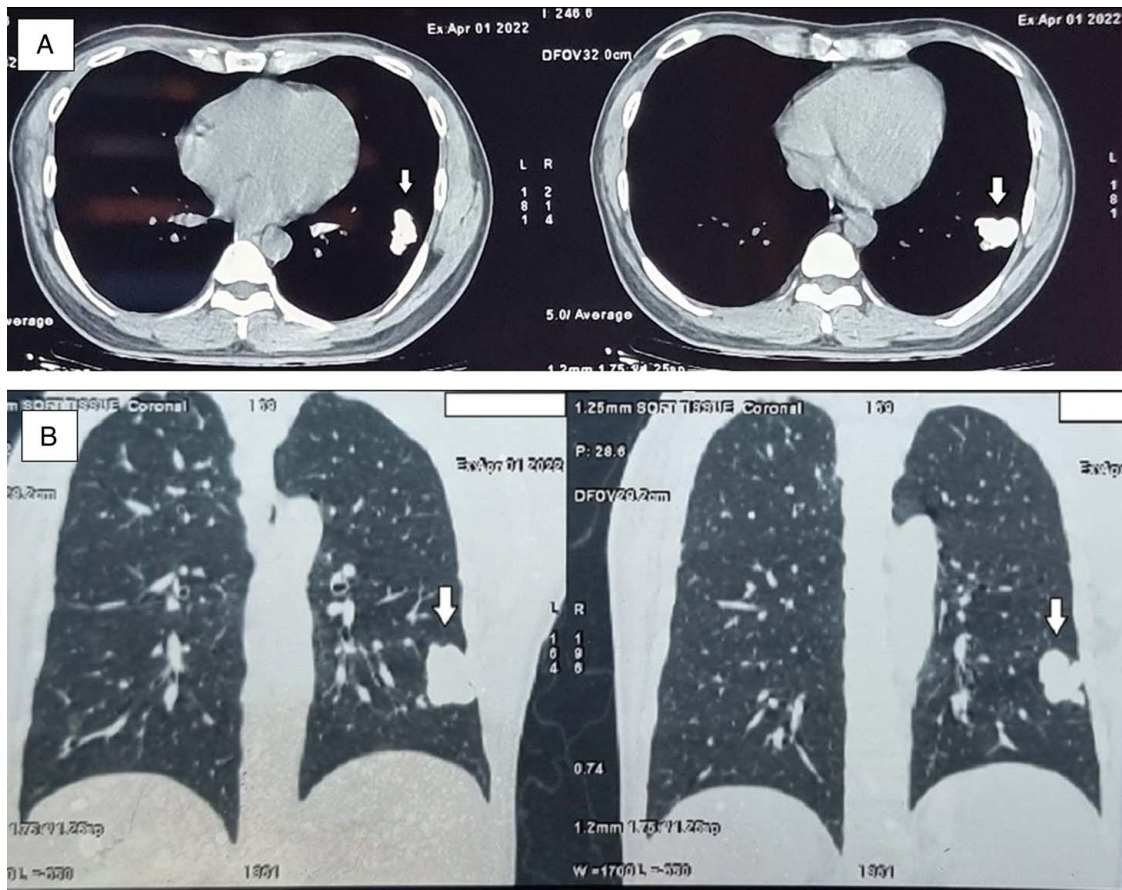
Axial mediastinal window (A) and coronal lung window (B) non-contrast enhanced computed tomography image.
